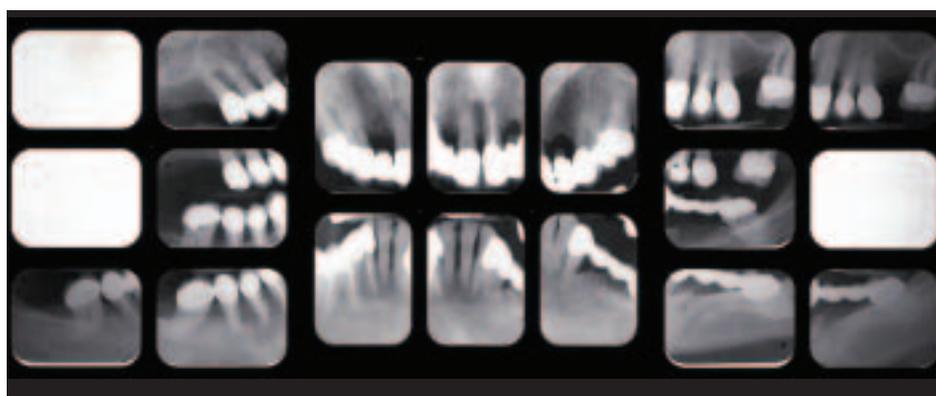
A review of the full-mouth x-ray taken 9 months before treatment.
